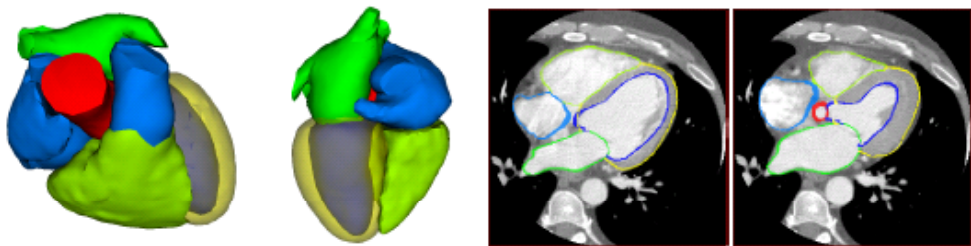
Cardiac mesh (seen from top right and bottom) and segmentation examples in axial CT slice for end-diastole and end-systole of the same patient. For the left ventricle, we model both the endo- and the epicardium [dark blue inside yellow]. All other chambers are modeled by endocardial walls. Vessels are arbitrarily truncated.
